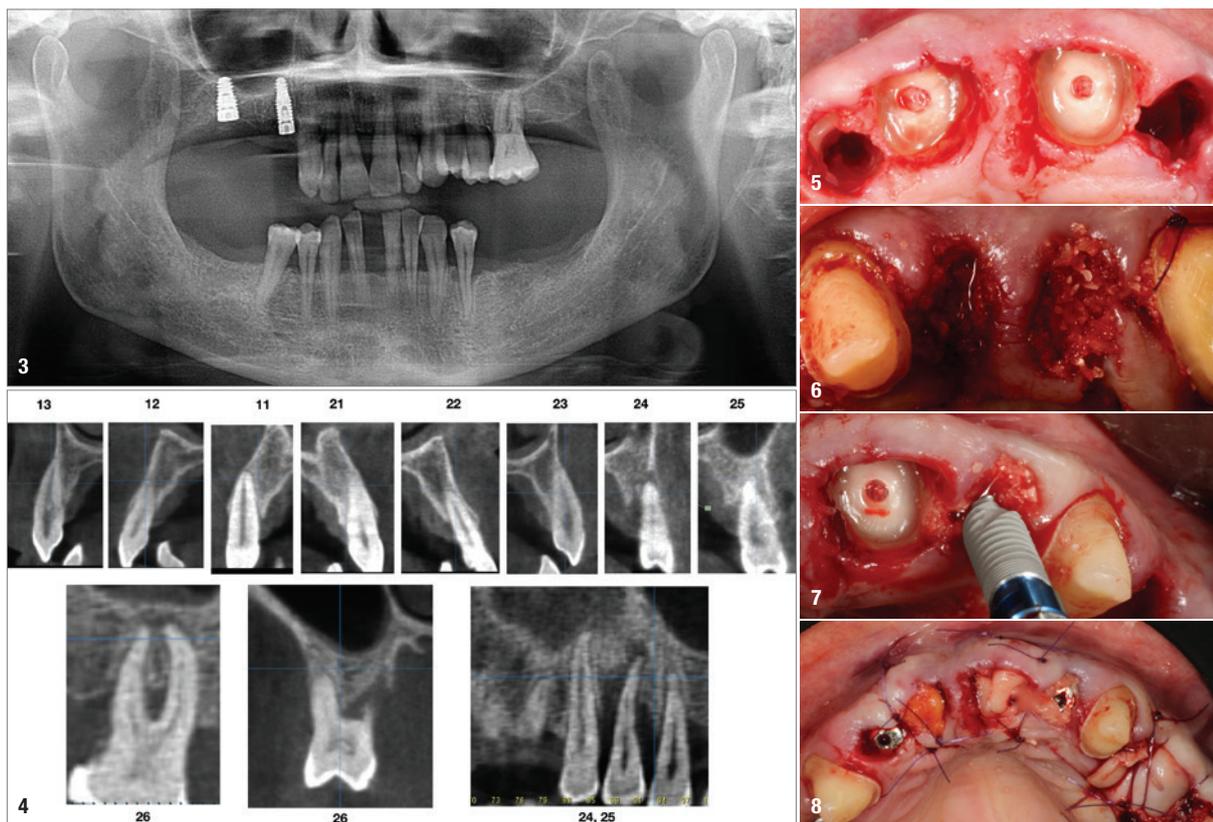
Initial radiograph before treatment. Fig. 4: CBCT scan showing the bone condition of the maxillary teeth. Vertical resorption and reduced thickness of the buccal bone plate of the right and left central incisors were evident. Fig. 5: Clinical situation after partial extraction of tooth #12, extraction of tooth #22, and root submersion of teeth #11 and 21. Fig. 6: Clinical situation after extraction of teeth #24 and 25 and augmentation with autologous dentine. Fig. 7: Immediate implant placement into the fresh extraction socket of tooth #22 after ridge grafting with autologous dentine. Fig. 8: Clinical situation after completion of first-stage surgery.
